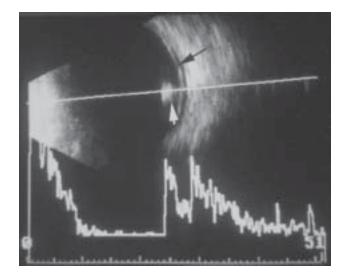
A combined A- and B-scan ultrasound of a penetrating injury with retained metallic intraocular foreign body (IOFB). The vector line for the A-scan passes through the metallic foreign body and indicates an initial high reflectivity spike and high internal echoes, indicated by the A-scan scale at the bottom of the scan. On the B-scan, the white arrow demonstrates "tailing" of echoes posterior to the metallic foreign body. The black arrow shows a low-lying retinal detachment. Echography scan: Courtesy of Ophthalmology Service, Brooke Army Medical Center, Fort Sam Houston, Tex. vances in electronic miniaturization, portable echography is readily available at forward locations on the battlefield to evaluate ocular injuries with an IOFB. Ultrasonic characteristics of an IOFB include
